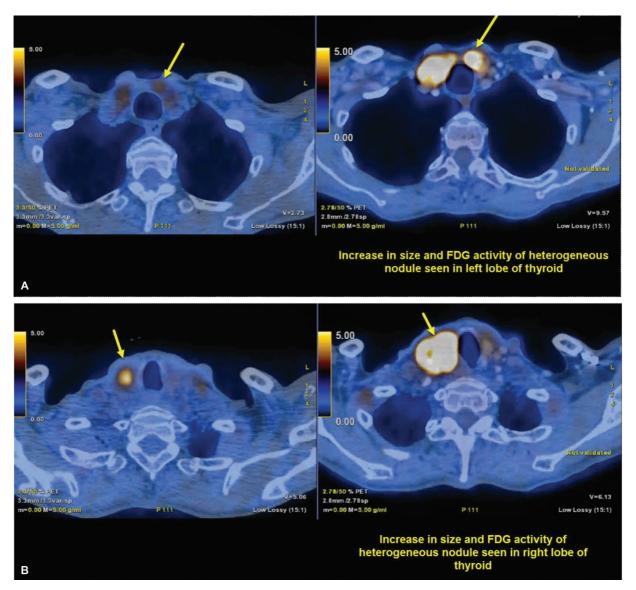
FDG-avid (SUV max. 15.5) heterogeneously enhancing nodules were seen in both lobes of the thyroid.
